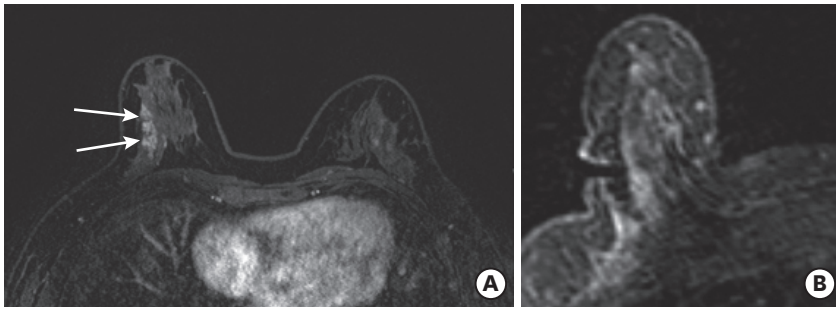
A 45-year-old woman with ADH underestimation case. (A) Axial T1-weighted fat-suppressed contrast-enhanced MR images show segmental heterogeneous non-mass enhancement in the right upper outer quadrant (arrows) on the early phase image. The lesion is categorized under BI-RADS 4C. (B) MRI-guided VAB was performed. The biopsy result was ADH. Subsequent surgery after US-guided wire localization for the area with post-VAB changes revealed IDC. ADH = atypical ductal hyperplasia; MR = magnetic resonance; BI-RADS = Breast Imaging Reporting and Data System; MRI = magnetic resonance imaging; VAB = vacuum-assisted biopsy; US = ultrasound; VAB = vacuum-assisted biopsy; IDC = invasive ductal carcinoma.
